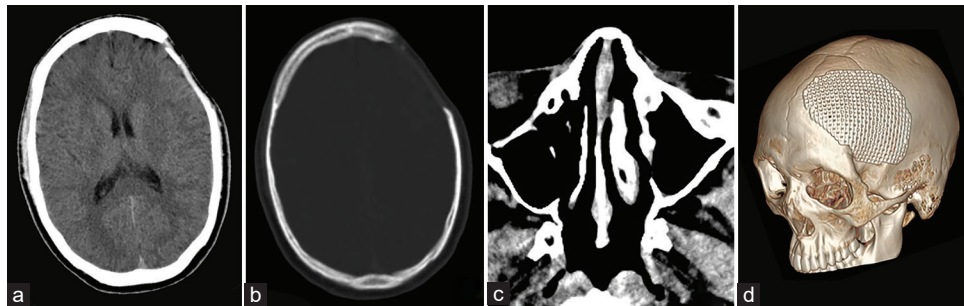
Head CT, a subsequent CT scan 3 months after surgery showed no signs of infection (a-c). Cranioplasty with titanium mesh was performed 9 months after surgery (d).
